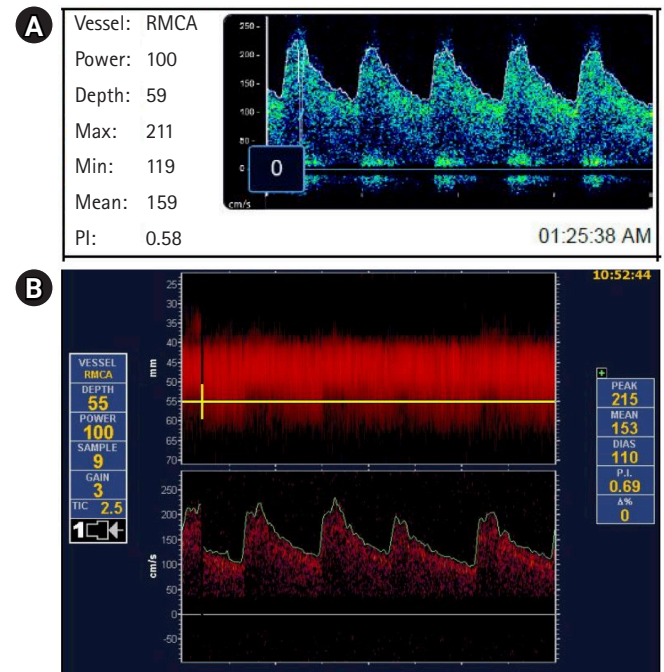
(A) Robotic and (B) manual transcranial Doppler waveform of the right middle cerebral artery (MCA) of patient 1 on postictus day 10 demonstrating elevated right MCA mean flow velocity, consistent with vasospasm in both techniques.
